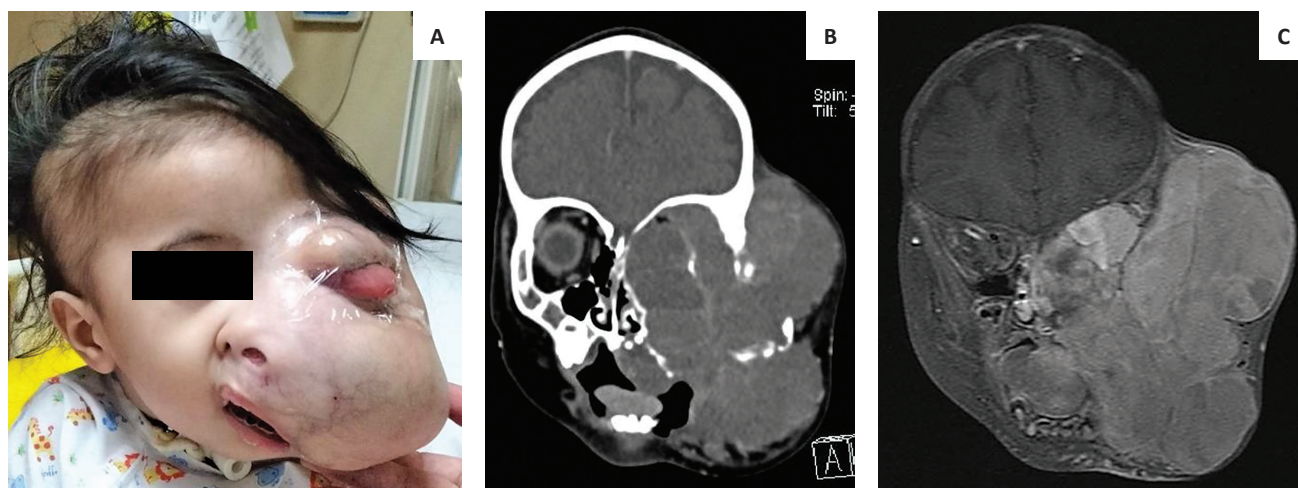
Clinical findings and imaging, recurrent lesion. (A) Gross structure of tumor at 14 months of age; (B) Cranial C scan; and (C) MRI showing the invasion of tumor to adjacent bone and soft tissue structures.
